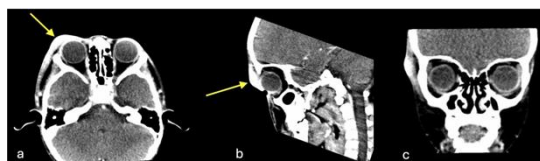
Orbital CT-scan with contrast revealed a,b) thickening of the skin-subcutaneous tissue with enhancement after contrast in the right preseptal orbital region, involving the superior eyelid, medial canthus to the subcutaneous temporal region on the right, fat stranding in the subcutaneous fat and periorbital fat; c) no abnormalities in the intracranial structures visualized, with mucosal thickening in the right and left frontal sinuses and right and left ethmoid
